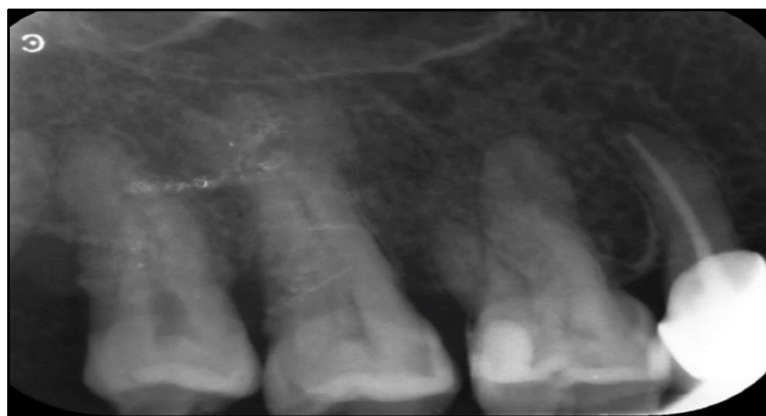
Periapical radiography from the relevant region, revealed dentin caries and a radiopaque image with a rim of radiolucency at the vital right maxillary second molar apices.
